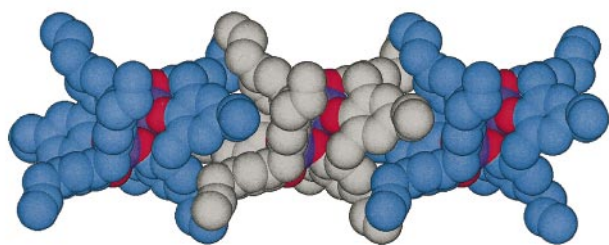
A portion of the X-ray structure of the koilate formed by self-inclusion of the koiland 16. The one-dimensional network is obtained by a single translation of the assembling core defined by the inclusion of the allyl moieties acting as internal connector into the cavity of the consecutive koiland 16. For the sake of clarity, the carbon atoms of the consecutive koilands are differentiated by colour and the hydrogen atoms are not presented.
